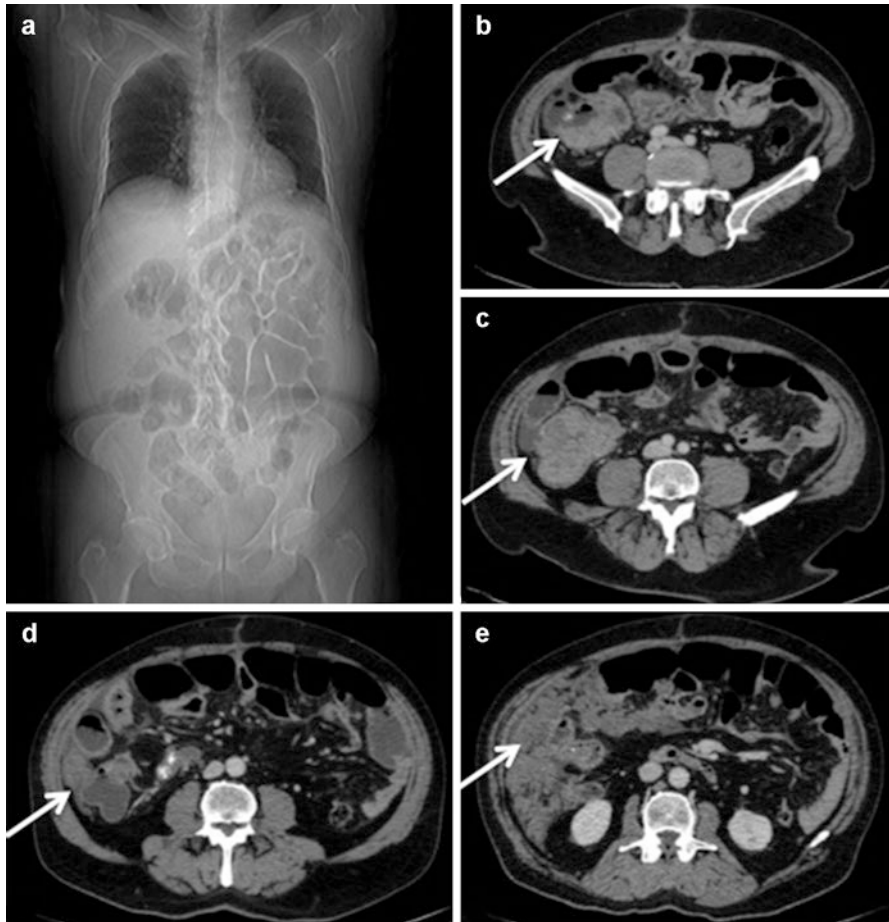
CT scout with diffuse ileal occlusion in peritoneal carcinomatosis (a). Advanced right colic cancer (b, c: *white arrows*). Peritoneal carcinomatosis from right colic cancer (d, e: *white arrow*)
